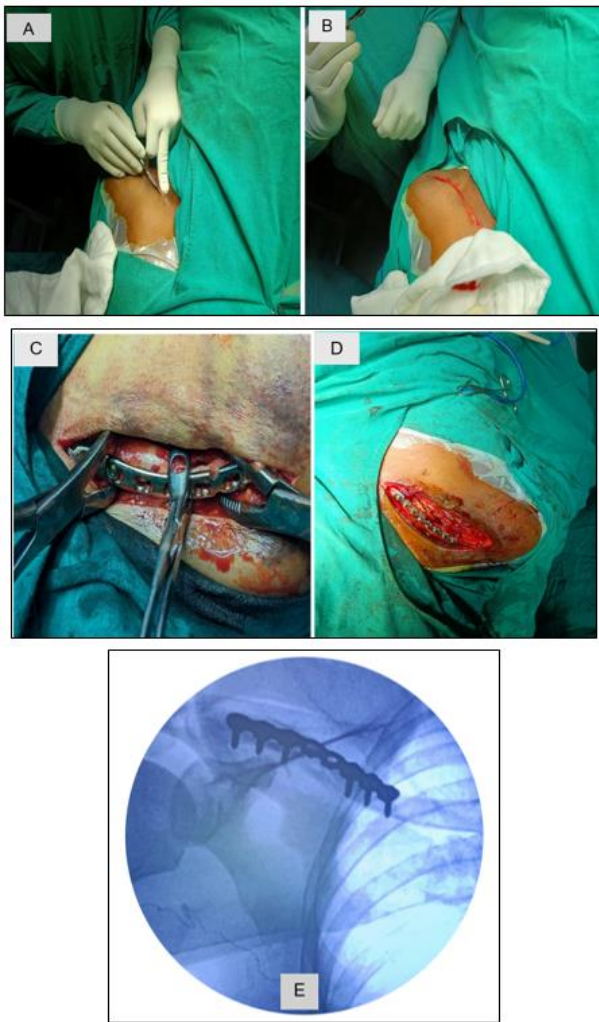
A): Intraop incision; B): Preoperative bony landmark markings; C,D) Intraop precontoured clavicular plate being fixed; E): Immediate postop x-ray with clavicular plate fixation
